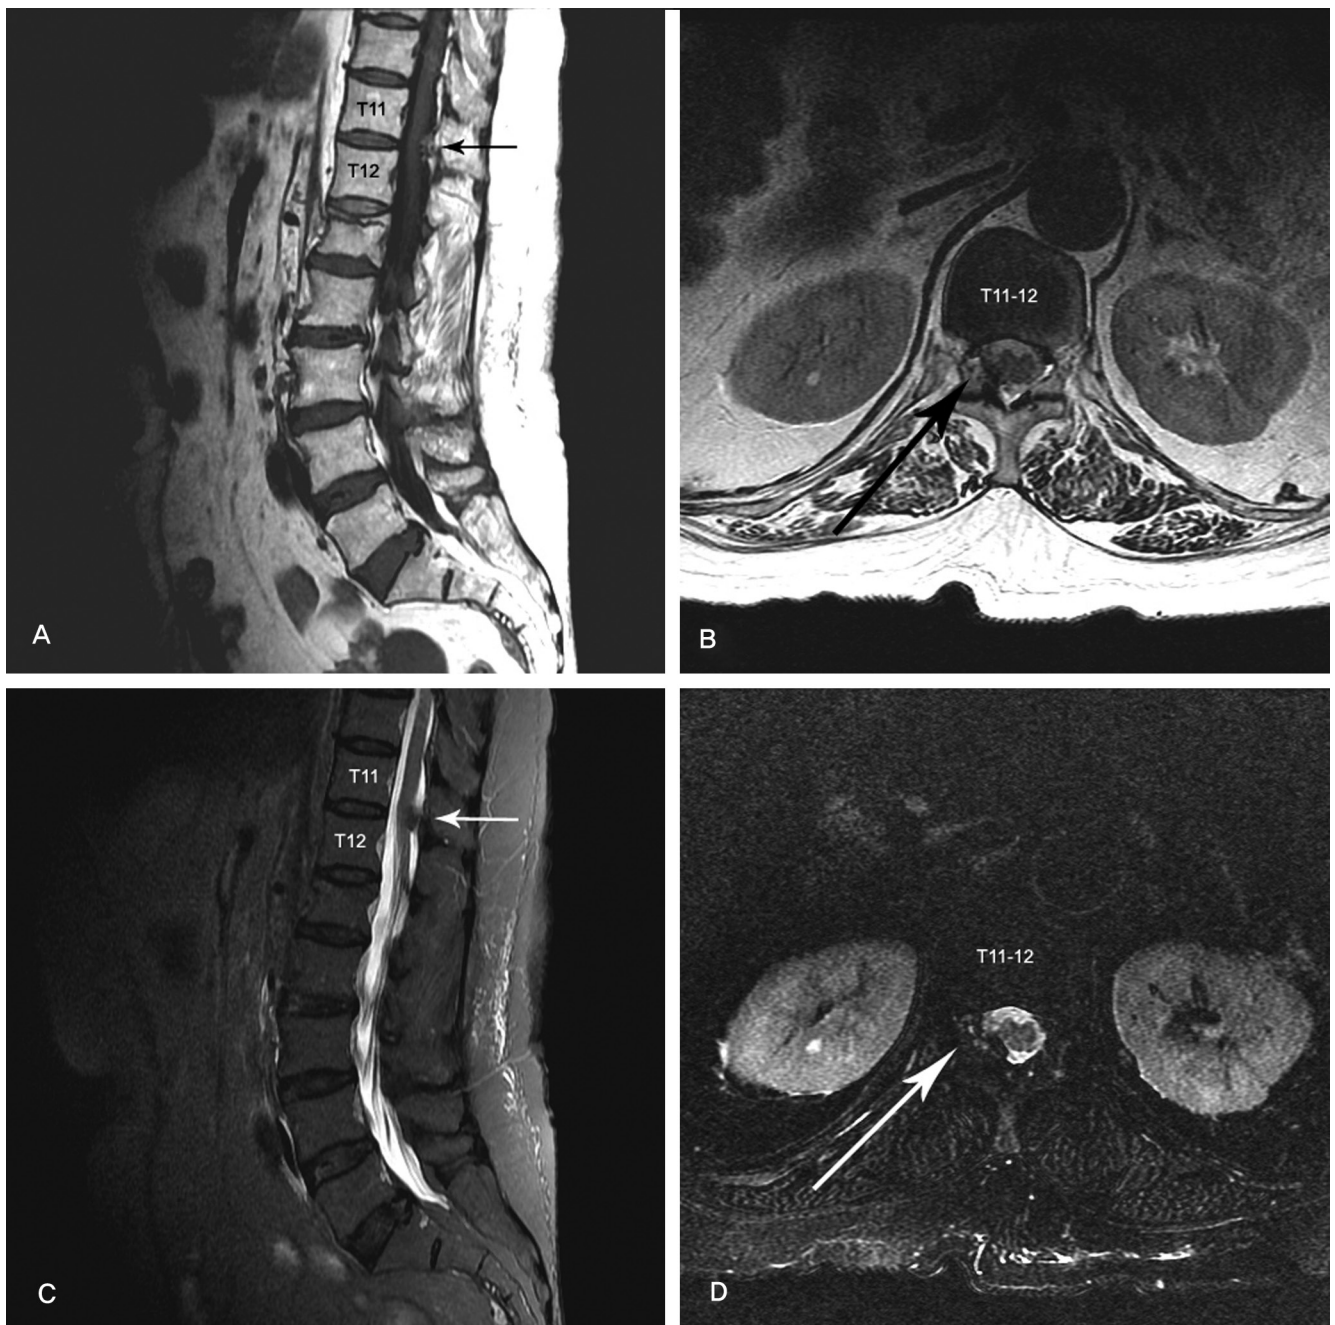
Magnetic resonance image of the thoracic spine showing a round extradural mass at the T11–12 level. The lesions show an inhomogeneously hypointense signal on the T1-weighted image (A, B), and a more hypointense signal on the T2-weighted image (C, D).
